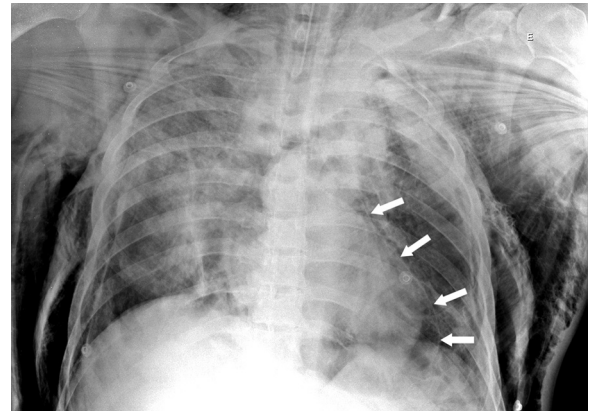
Portable X-ray film obtained in the Emergency Room, after intubation. White arrows indicate pericardium stripe and its underlying pneumopericardium.
